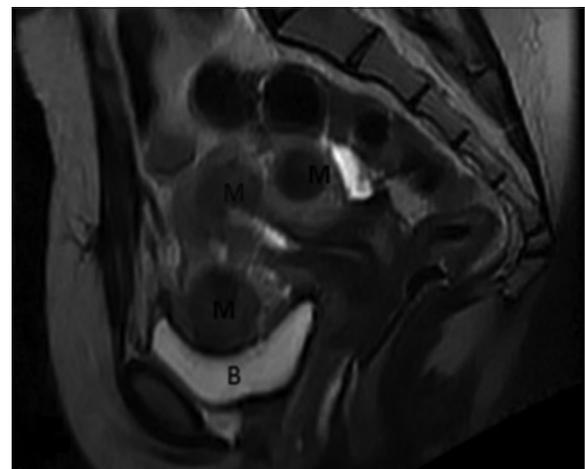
Midsagittal T2-weighted magnetic resonance image of the pelvis demonstrating bulky uterus with multiple (three) well-defined hypointense intramural masses (M) with resultant indentation of the urinary bladder dome (B)
